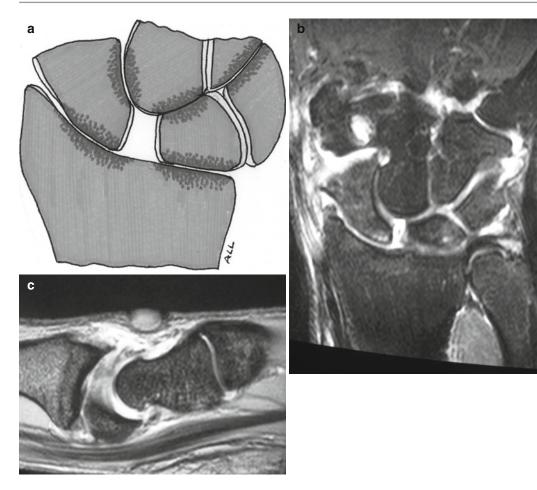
(a) In stage V SLAC and SNAC wrists, degenerative arthritis can be observed between the radius and the lunate. (b) MRI in the frontal plane of a stage V SLAC wrist in which the midcarpal joint is better preserved than the radio-lunate joint. (c) MRI in the sagittal plane
